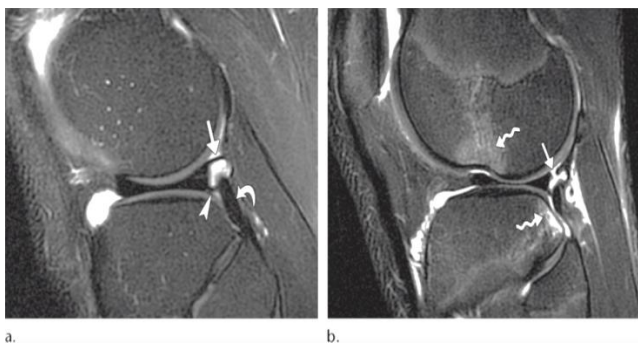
Popliteomeniscal fascicles. (a) Sagittal T2-weighted fat-suppressed MR image in a 25-year-old man shows the normal posterosuperior (straight arrow) and anteroinferior (arrowhead) popliteomeniscal fascicles forming the roof and floor of the popliteus hiatus, respectively. The popliteus tendon (curved arrow) is seen as it begins its course into the hiatus. (b) Sagittal T2-weighted fat-suppressed MR image in a 33-year-old man shows a torn posterosuperior popliteomeniscal fascicle (straight arrow). This injury has a high association with tears involving the posterior horn of the lateral meniscus. The patient also suffered an anterior cruciate ligament injury (not shown), with associated "kissing" contusions (wavy arrows) involving the lateral femoral condyle and posterior aspect of the lateral tibial plateau(28).
